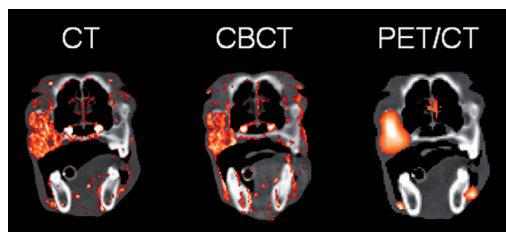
Left: Conventional CT with contrast enhancement overlay. Middle: CBCT with contrast enhancement overlay. Right: Conventional CT with FDG-PET overlay. High uptake/enhancement is indicated by bright colours. The CT and PET/CT images are taken three days before treatment start, the CBCT image is taken prior to the first treatment.
